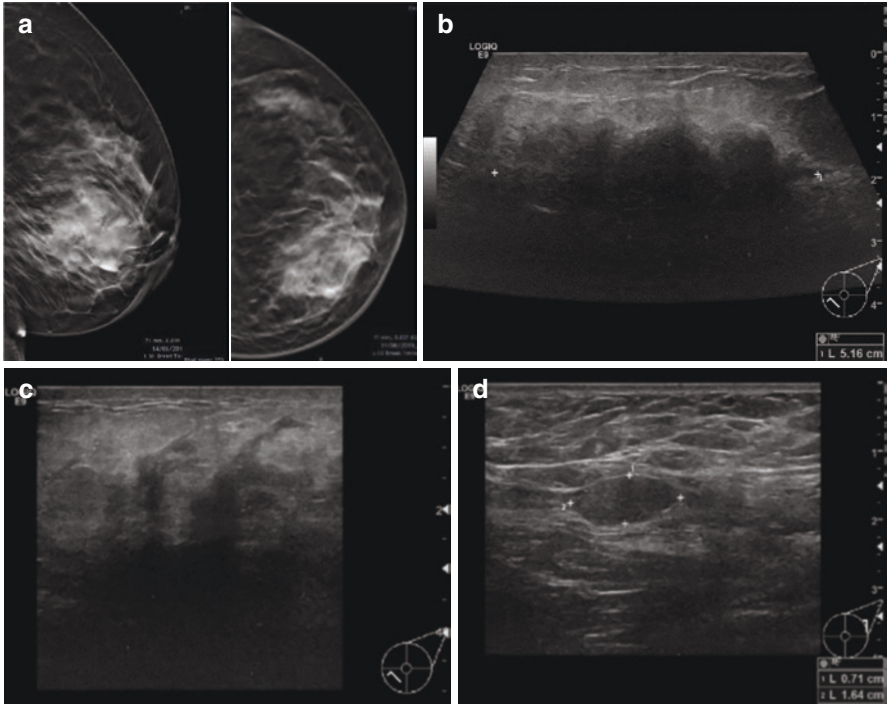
(a) A 50-year-old woman with a firm mass in the left breast with nipple retraction suspicious for inflammatory carcinoma. Left: tomosynthesis images – there is dermal thickening and an ill-defined 85-mm retroareolar mass. (b) Ultrasound shows multiple hypoechoic mass lesions which are ill-defined. (c) This is associated with increased dermal thickening and increased echogenicity of the intramammary fat mimicking inflammatory carcinoma. (d) Enlarged left axillary nodes are also present. Core biopsy of the mass and axillary node showed granulomatous mastitis and reactive axillary adenopathy
